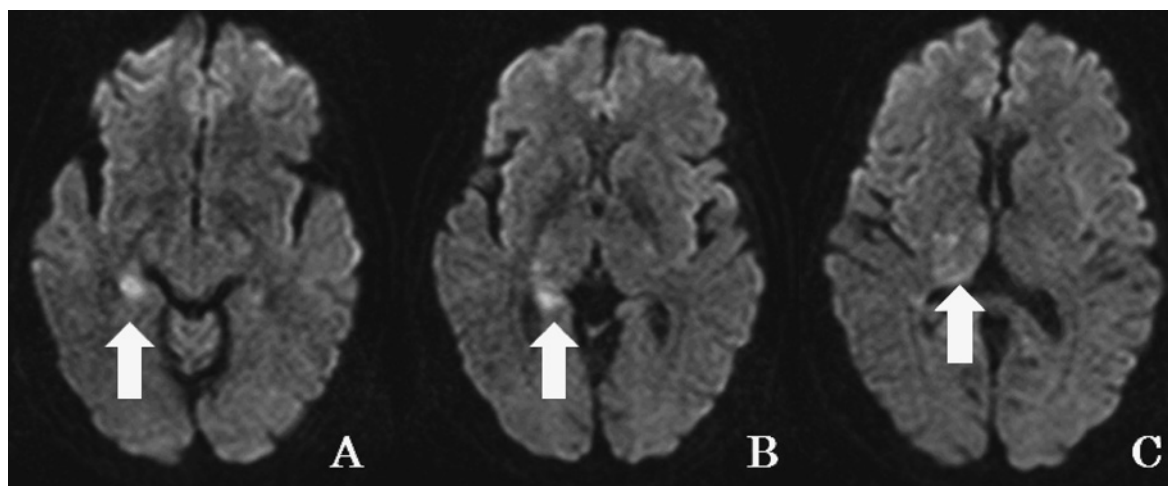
Diffusion-weighted images (DWI) with strong signals
